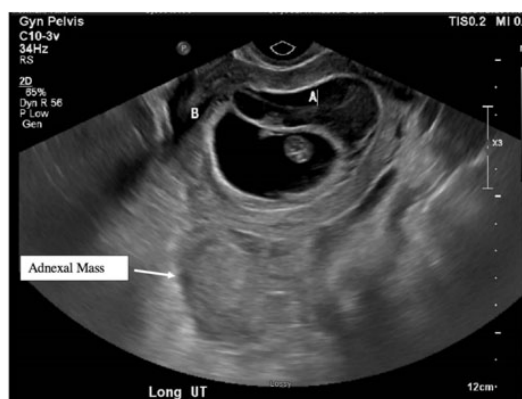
Additional longitudinal view of the uterus on transvaginal ultrasound showing two intrauterine gestational sacs and an indeterminate heterogenous, adnexal mass posterior to the uterus.
